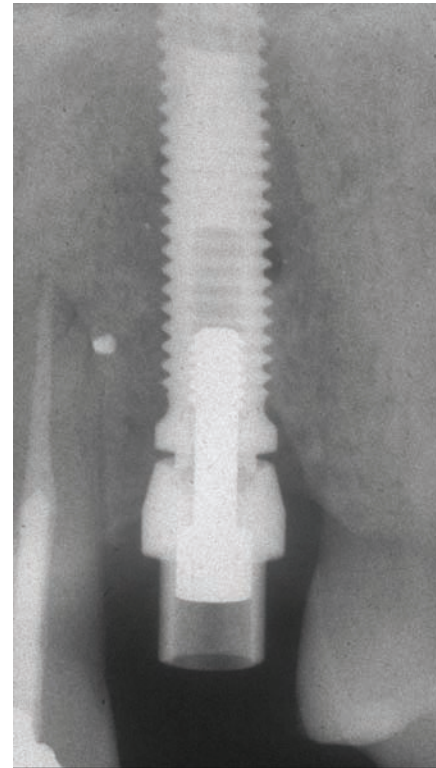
A periapical radiograph demonstration failure to correctly seat a standard abutment onto an external hex Nobel Biocare implant.
